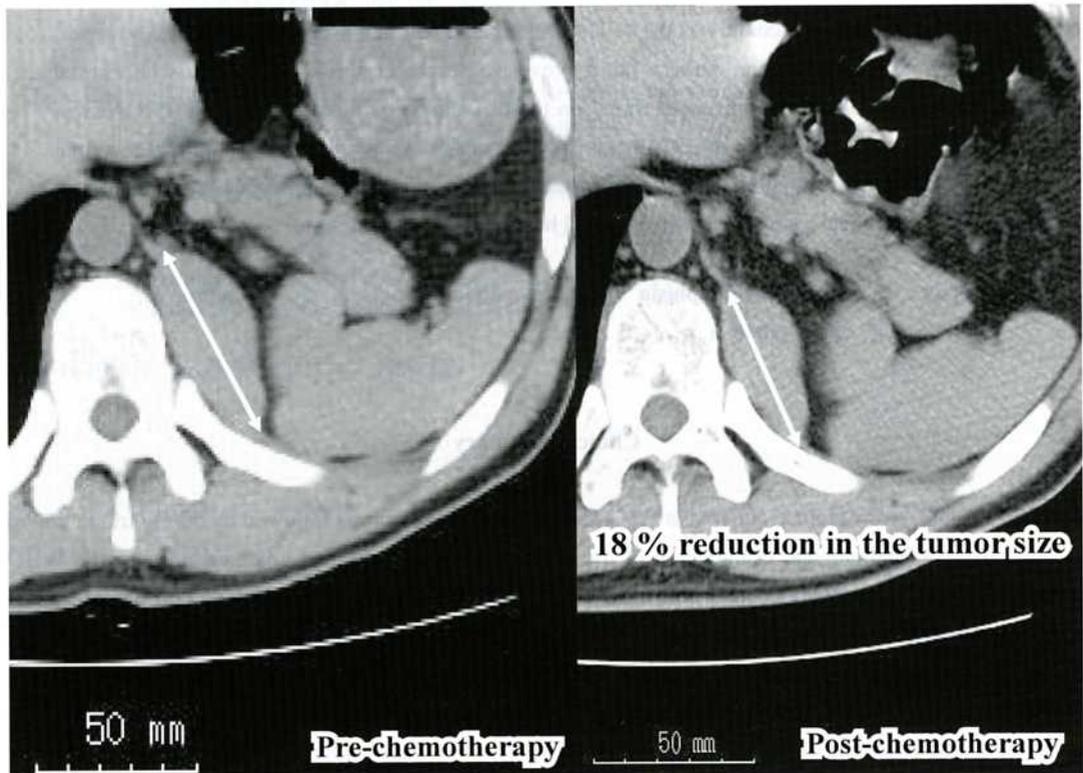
Chest computed tomography shows the response to the chemotherapy was stable disease (SD, 18% reduction in the tumor size) according to Response Evaluation Criteria in Solid Tumors (RECIST).
